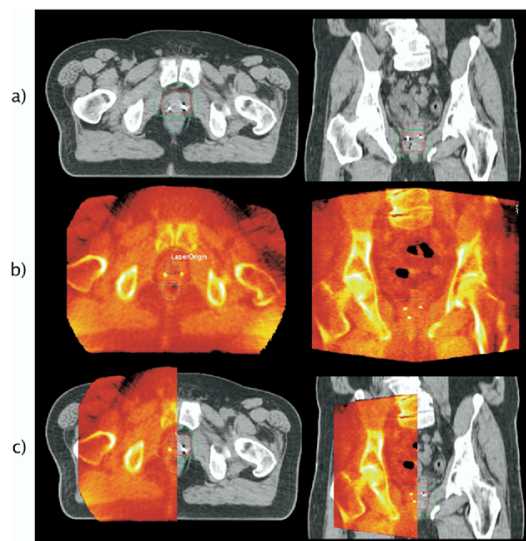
A comparison of (a) a reference planning CT (gray) of a prostate patient, (b) an MV CBCT of the patient lying on the treatment table (color), and (c) a fusion of the 2 images. With an MV CBCT of 14.4 MUs, structures such as the prostate, rectum, fat, muscles, bone, and gold seeds are visible. Registration can be done automatically or manually using the 3 typical views (axial, sagittal, and coronal). The planning contours and the points of interest can be displayed on the MV CBCT to facilitate the registration.
